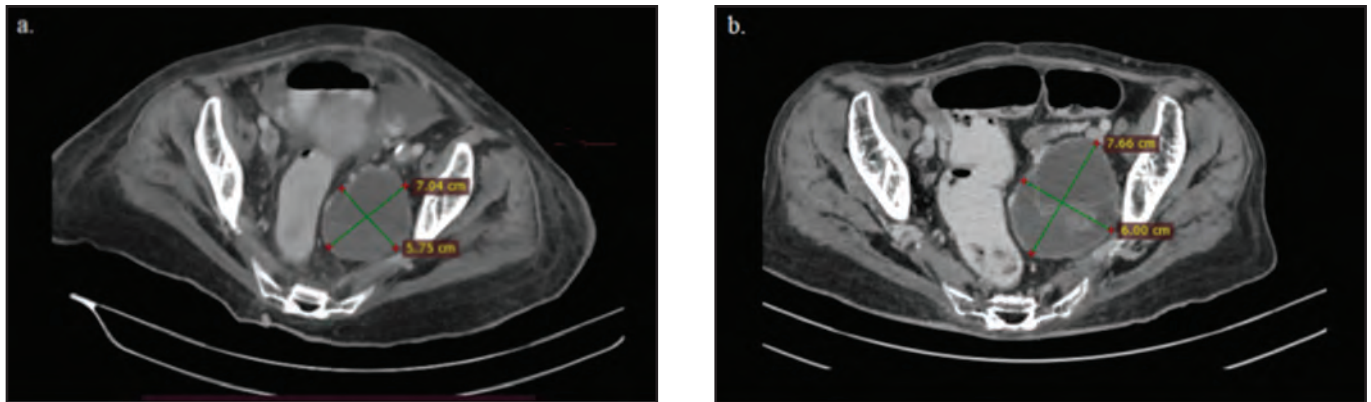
CT showing (a) left lateral pelvic hypodense lesion (5.75 x 7.04 cm). (b) multilobulated heterogenous left pelvic enhancing lesion (7.66 x 6.00 cm).
